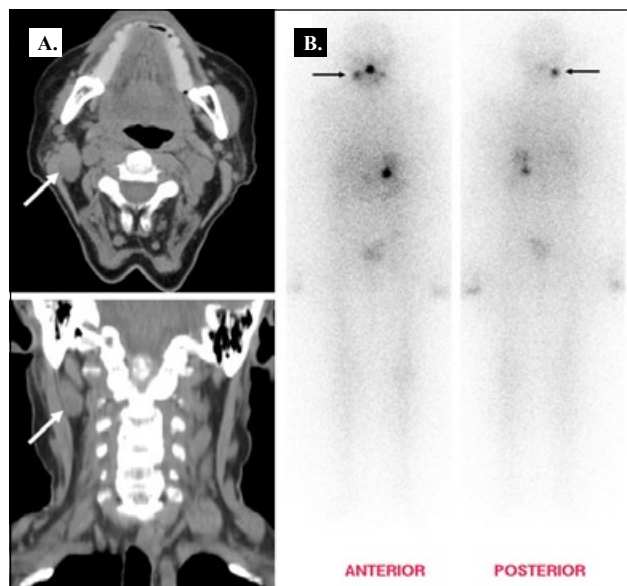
A: Non-contrast CT of the neck showing an enlarged right level 2, cervical lymph node. B: Post-treatment ^{131}I whole body scan showing tracer accumulation within the superior right neck corresponding to the cervical node on CT. There is also tracer accumulation in the midline, stomach, bowel and urinary bladder which is physiological.
